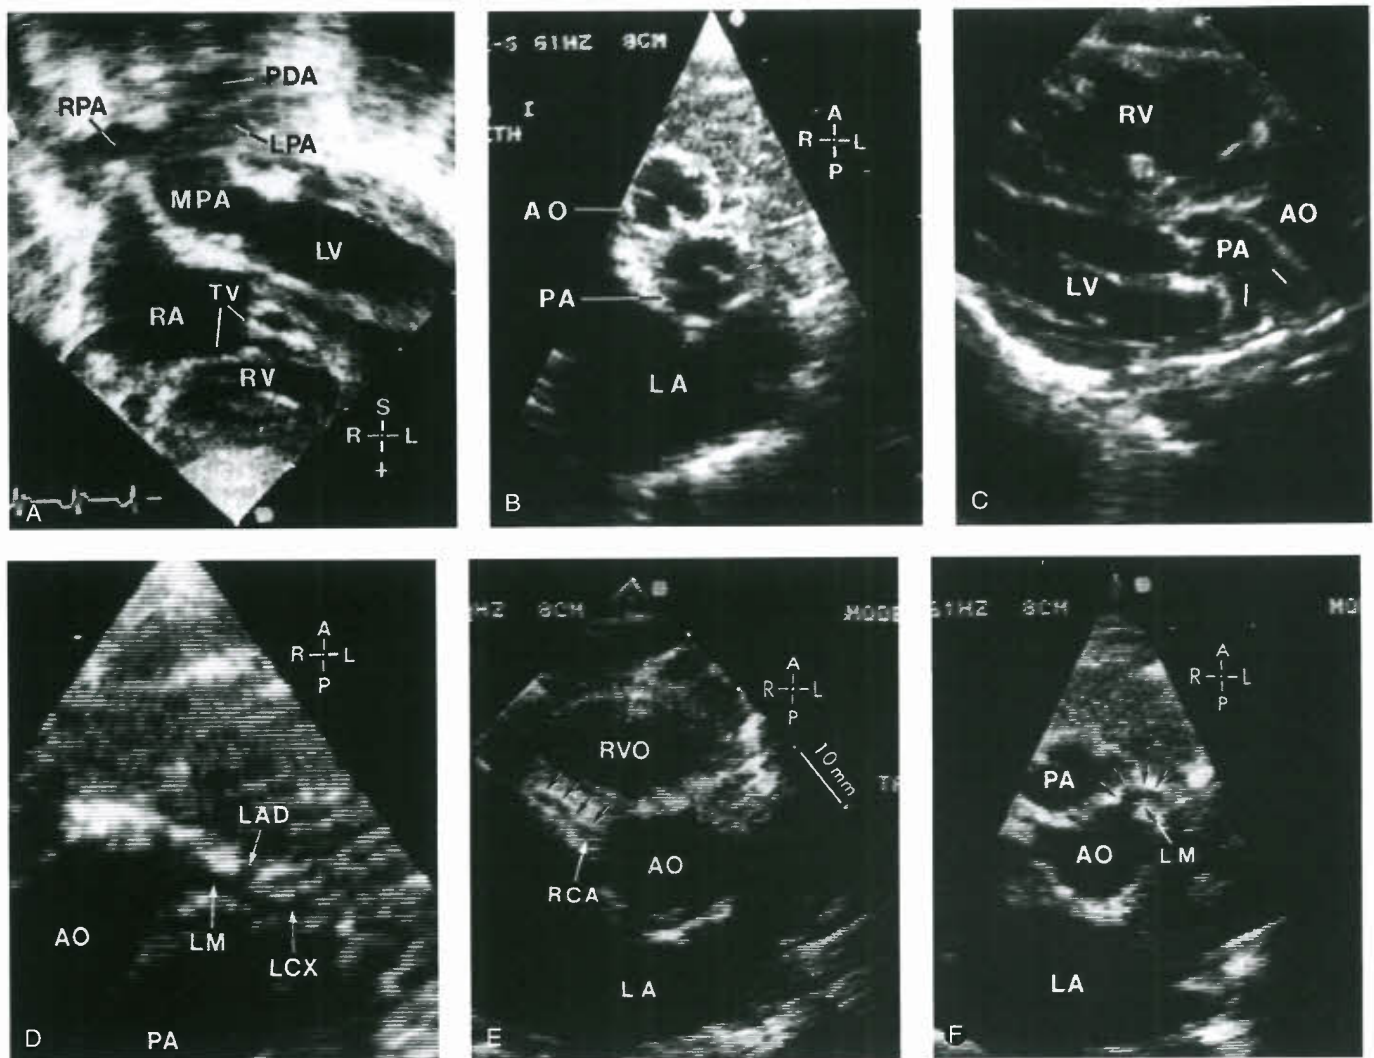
Two-dimensional echocardiographic images in 1-day-old with TGA/IVS. A: Subcostal view demonstrates left ventricle (LV) and unobstructed LVOT aligned (connected) with normal pulmonary (potential neo-aortic) valve, main (MPA), right (RPA), and left (LPA) pulmonary arteries. A large PDA is seen (on prostaglandin E1 infusion). B: Parasternal short-axis view demonstrates slightly oblique interrelationship of the great arteries consistent with TGA [S,D,D] (AO). LA, left atrium; PA, pulmonary artery. C: Parasternal long-axis view confirms discordant ventriculoarterial connection: the pulmonary trunk by its abrupt posterior turn shortly distal to the pulmonary valve, and (in other planes of this echo view) the aorta by the origin of the brachiocephalic artery. D: Origin and proximal branches of the left coronary artery in the usual coronary artery anatomy for TGA (see also Fig. 49.7). Note origin of left main coronary (LM) from left/posterior facing sinus and its bifurcation into proximal left circumflex (LCX) and anterior descending (LAD) branches. The right coronary artery, in another echo plane, arises from the posterior right aortic sinus. E,F: Echocardiographic images obtained at postoperative examination 1 year after surgery (arterial switch at 13 days of age) shows moderate dilation of the neo-aortic root. Right (RCA) and left main (LM) coronary arteries show no stenosis or obstructive kinking in the proximal segments. RVO, right ventricular outflow.
